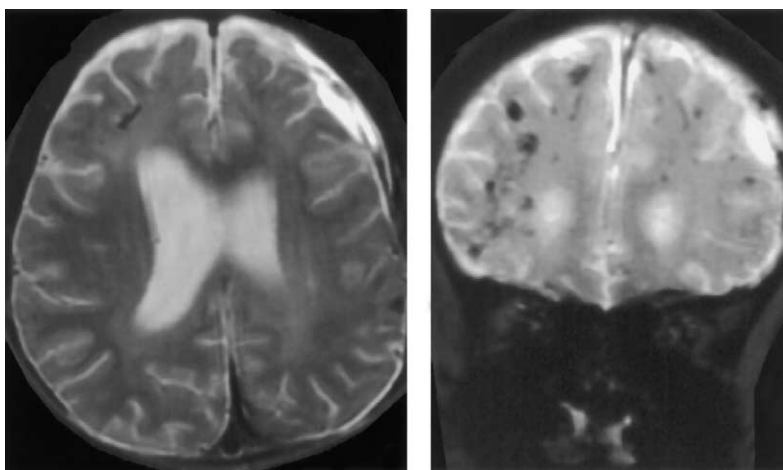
Axial T2-weighted imaging demonstrates small foci of sheer hemorrhage in the right and left frontal lobe and left temporal parietal region (*left*). Coronal gradient echo image, however, is clearly superior for the detection of sheer injury compared with conventional imaging. Note the numerous sheer injuries through the frontal lobes not readily evident on the T2-weighted images (*right*).
